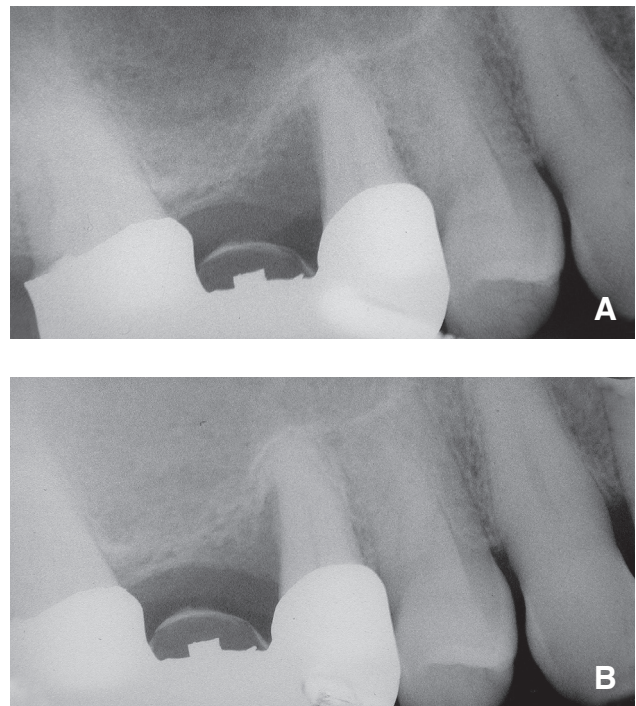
Detailed radiographs before (a) and three months after (b) the regenerative surgical procedure using NovaBone Putty® augmentation material for filling of the treated persistent intraosseous defect adjacent to the distal aspect of the single root of the right second upper premolar serving as a pillar tooth of the fixed bridge
